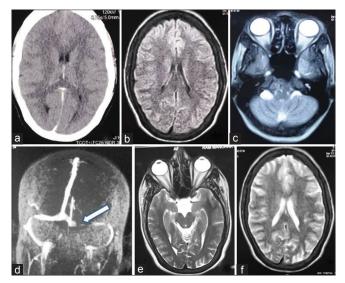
(a–f) Neuroimaging photographs. Axial contrast-enhanced computed tomography (a) and T2 flair magnetic resonance imaging of brain (b) along with T2 axial scan showing orbit and optic nerve (c) was normal. Magnetic resonance venography brain revealed left transverse and sigmoid sinus thrombosis (arrow) with minimal cerebral edema (d). T2 axial magnetic resonance imaging (e and f) at 3 months was normal
